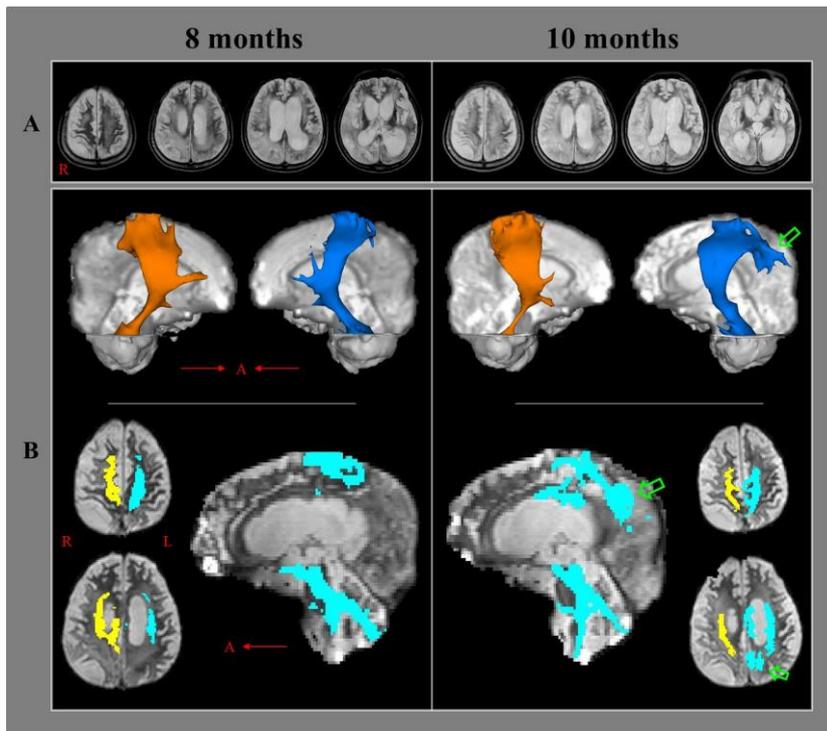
(A) Brain magnetic resonance images at eight months after onset show leukomalactic lesions in the fronto-parieto-temporo-occipital lobes in both hemispheres. (B) Results of diffusion tensor tractography (DTT) of the upper ascending reticular activating system between the thalamic intralaminar nucleus and the cerebral cortex. On 8-month DTT, decreased neural connectivity of the upper ARAS is present in both the prefrontal and parietal cortices. Compared with the 8-month DTT Results, the 10-month DTT revealed increased neural connectivity of the upper ARAS in the left parietal lobe (especially in the precuneus [arrows]) and the body of the corpus callosum.
